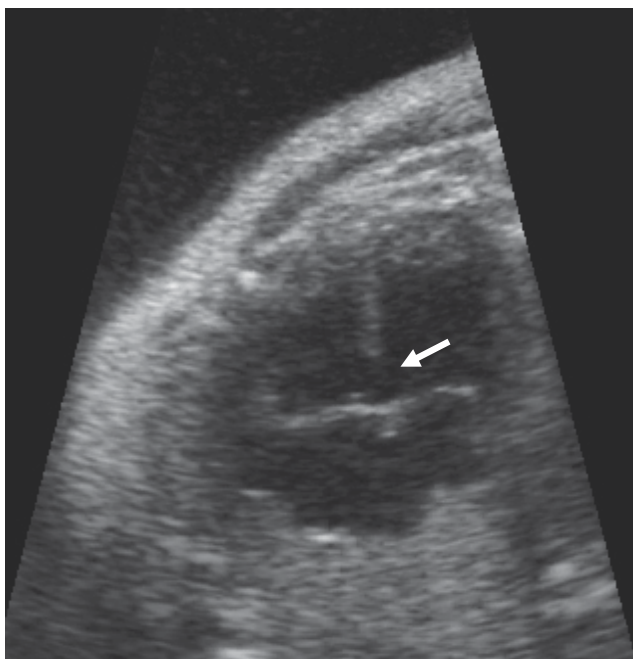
Image of fetal ultrasonography: interventricular communication associated with Diabetes Mellitus
